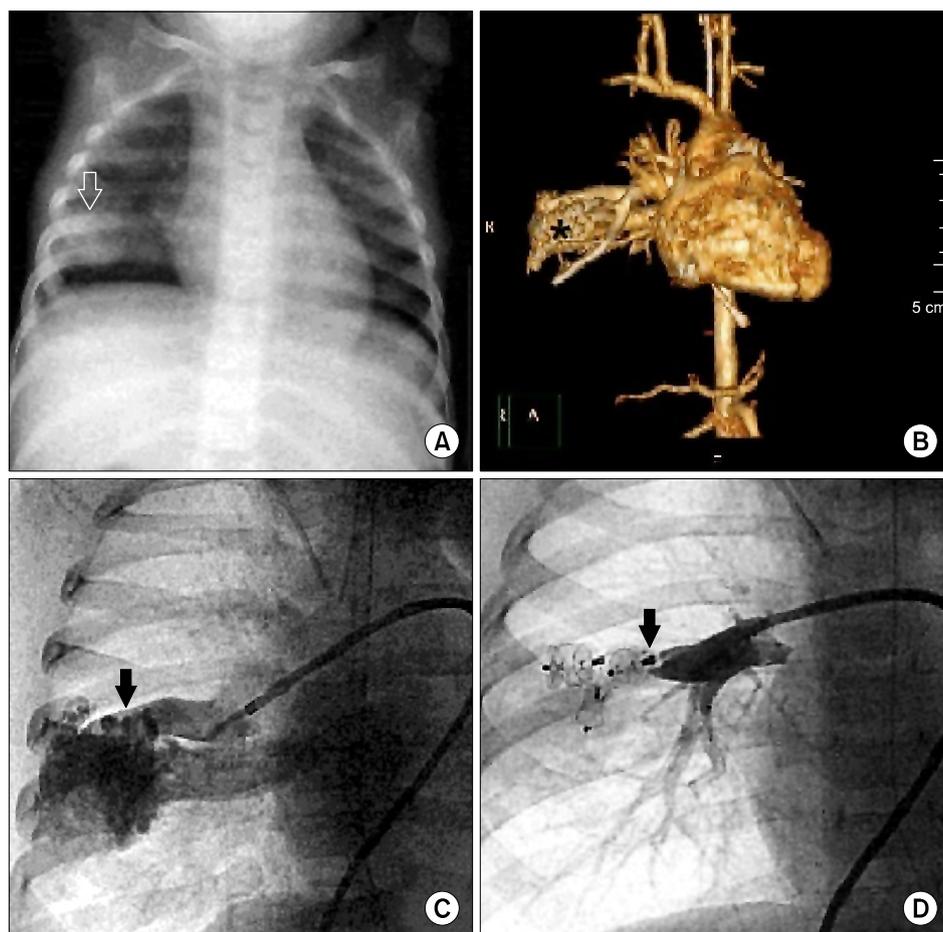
(A) Chest X-ray showing an ill-defined mass (arrow), (B) Reconstruction view of the chest computed tomography showing an enhanced conglomerated tortuous vascular mass (asterisk), connecting the pulmonary artery and vein, (C) Angiogram showing vessels feeding the PAVM (arrow), (D) Three Amplatzer vascular plugs placed to obliterate the PAVM (arrow).
